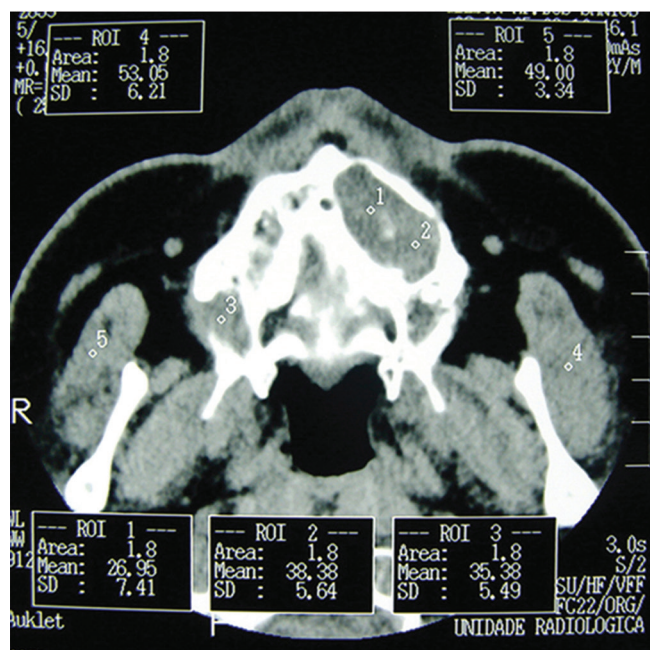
CT axial imaging showing maxillary expansion.
